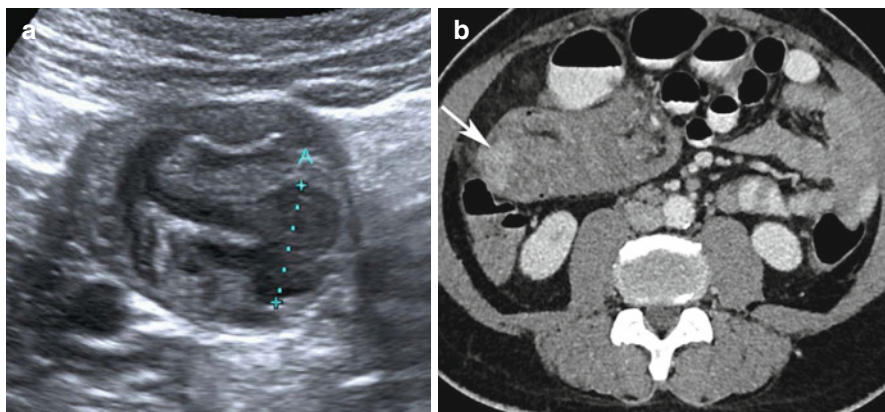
Intussusception due to small bowel NET. (a) Ultrasound demonstrates an intussusception, and the lead point is a small bowel NET, shown here between the calipers. (b) CT demonstrates the enhancement of the primary lesion
